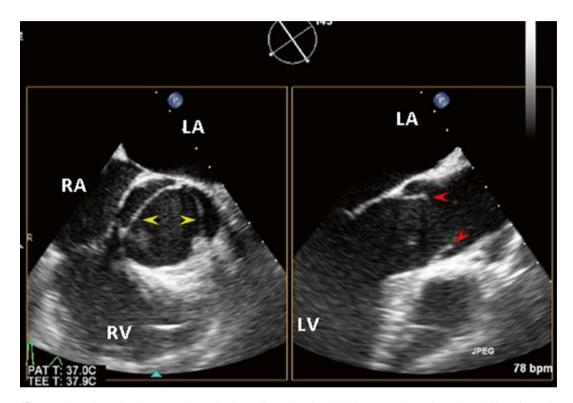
Two-dimensional transesophageal echocardiography (2D TEE) image, x-plane view, showed bicuspid aortic valve (*yellow arrows*) with oval shape orifice and doming sign (*red arrows*) in systole
